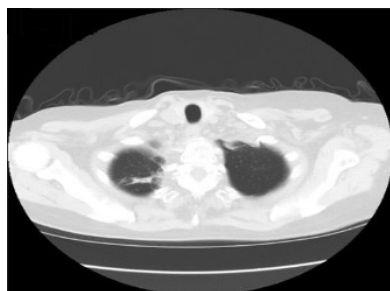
A chest CT showed remarkable tumor shrinkage.
